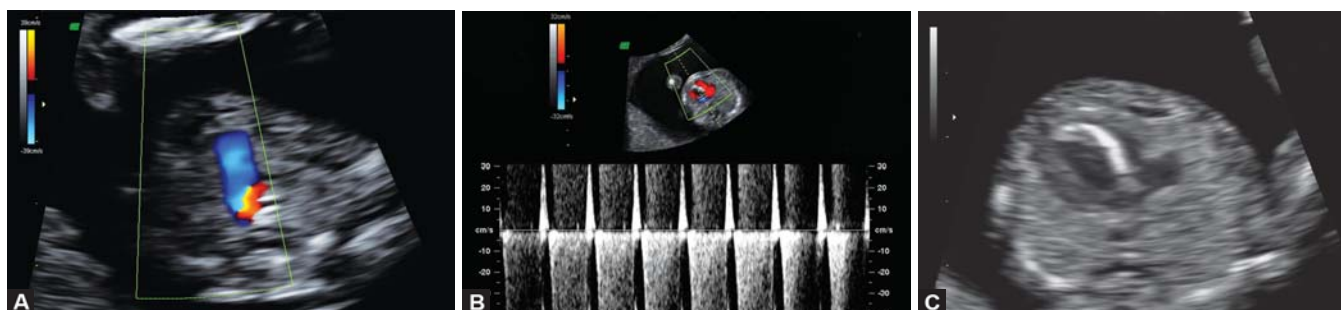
to C: Atrioventricular septal defect with unbalanced right ventricle dominance and double outlet right ventricle at 15 weeks' gestation. *Note:* The abnormal reversed A wave in the ductus venosus (A), the color Doppler flow through the atrioventricular septal defect with atrioventricular regurgitation (B) and the double outlet right ventricle with unbalanced right ventricle dominance (C)
